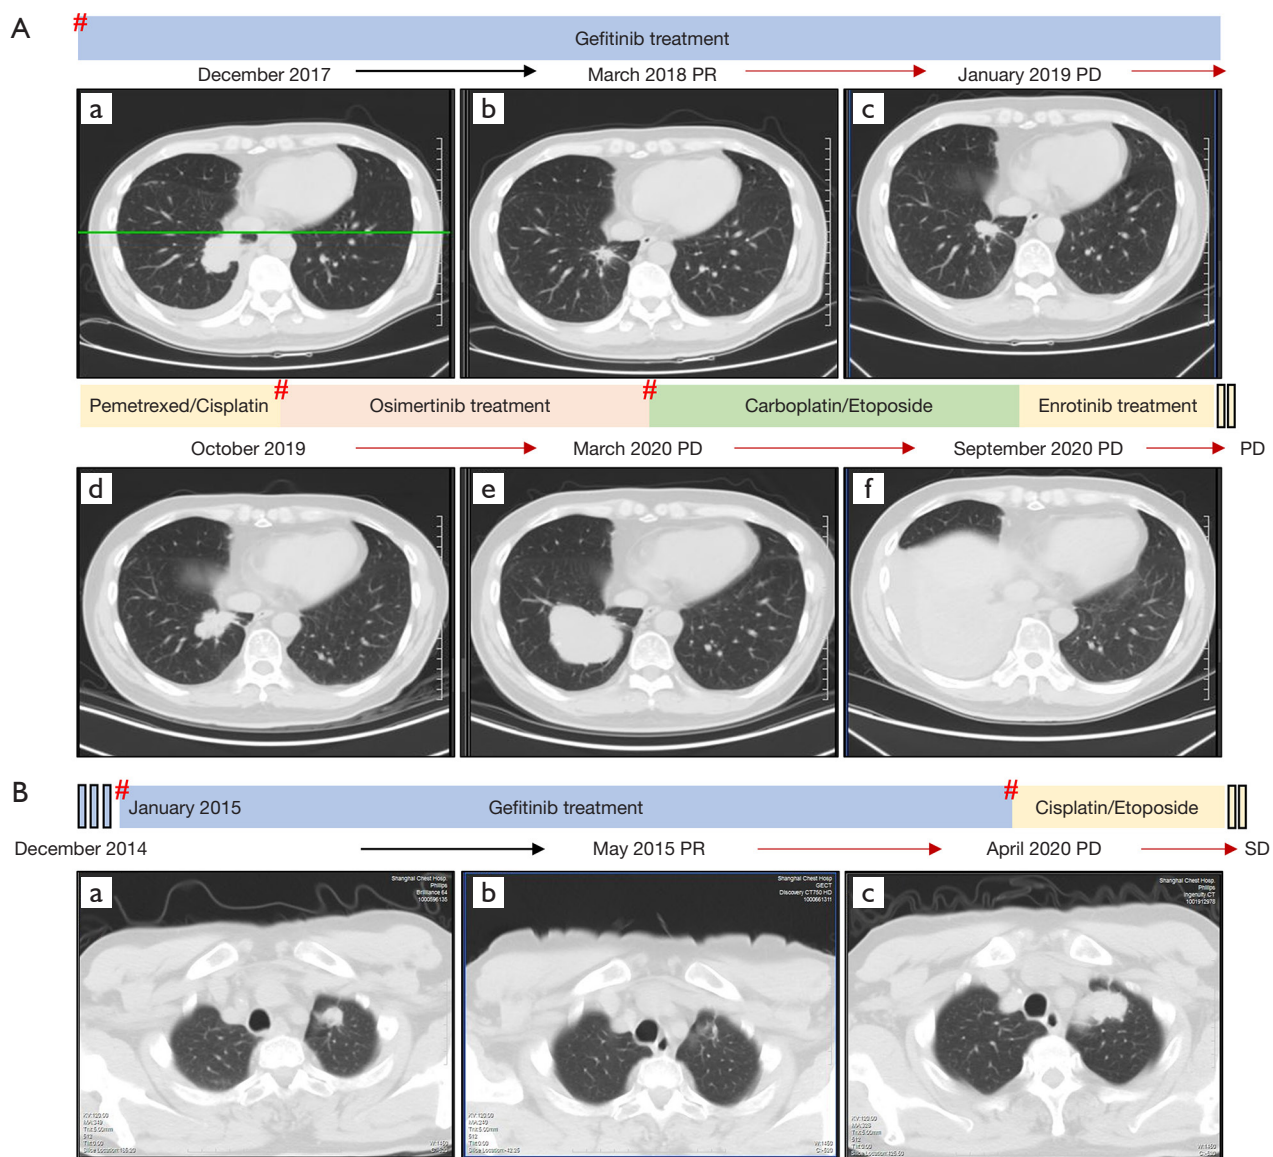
Tumor lesions detected by CT during the courses of the patients' diseases and treatment. (A) Case 1: (a) Before start of *EGFR*-TKI treatment. NGS showed *EGFR* exon 19 deletion. (b) PR after gefitinib treatment. (c) First progression after 12.5 months of gefitinib. (d) PD after 9 months of chemotherapy. *EGFR* T790M was detected. (e) Second progression after 4 months of osimertinib treatment. Appearance of the transformation to SCLC. *ETV1* p.E462Q was detected. (f) PD after 6 months of chemotherapy. (B) Case 2: (a) Before start of *EGFR*-TKI treatment. *EGFR* L858R was detected. (b) PR after 4 months of gefitinib treatment. (c) PD after 64 months of gefitinib treatment. *ETV1* p.P159S was detected. # represents the time point of NGS detection. NGS, next-generation sequencing; SCLC, small cell lung cancer; PR, partial response; PD, progressive disease.
